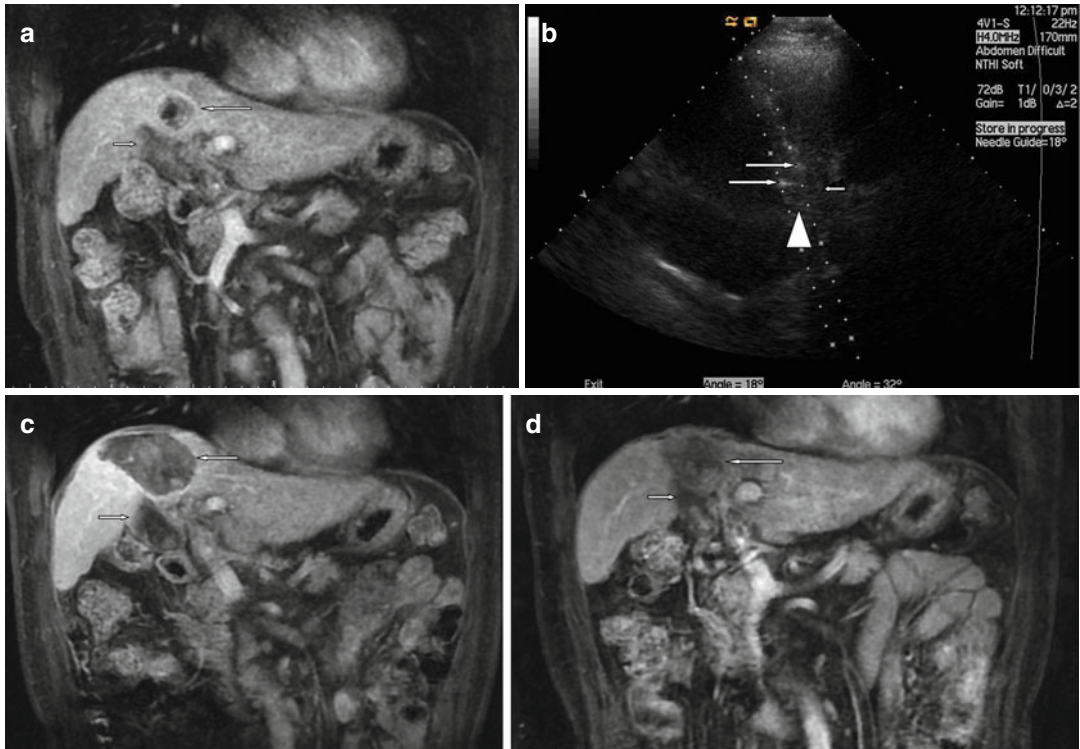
MWA in a 77-year-old man with HCC adjacent to the gallbladder. The tumor size is 3.1×3.0×3.0 cm. The distance between the gallbladder and tumor is 3 mm. (a) Preablation MRI scan shows an HCC lesion (*long arrow*) located adjacent to the gallbladder (*short arrow*). (b) Conventional ultrasound shows that two microwave antennas (*long arrow*) are placed in the tumor (*triangle*) and one temperature monitor (*short arrow*) is
